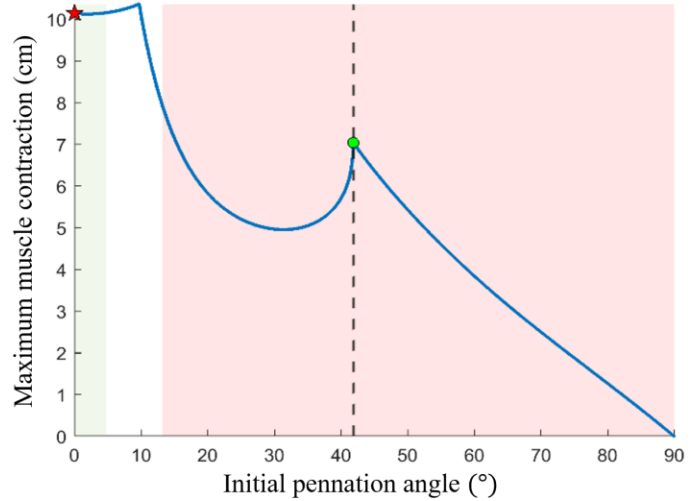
MAXIMUM MUSCLE CONTRACTION WITH RESPECT TO INITIAL PENNATION ANGLE
